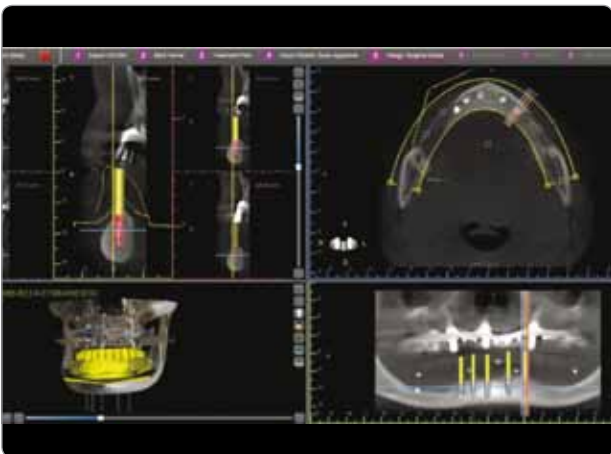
Digital planning (BlueSky Software) combines CT imaging and model scans.
